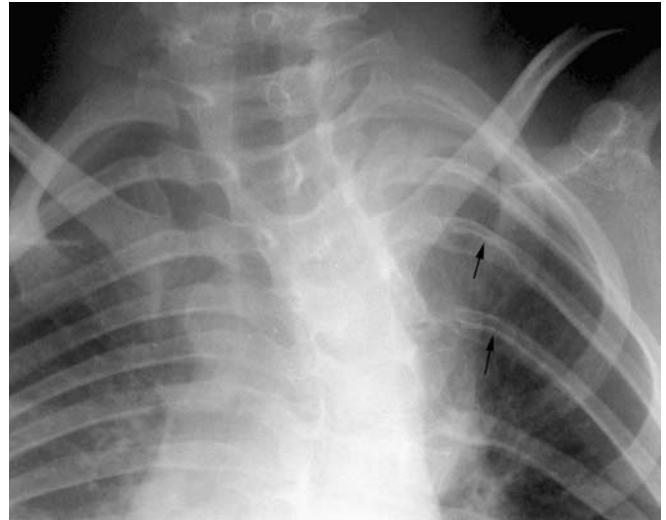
AP radiograph of the upper chest wall demonstrating rib pencilling (*arrows*)
